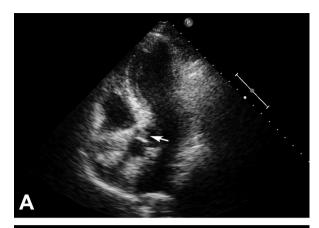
Transthoracic echocardiography (A) revealed a suspicious lesion (arrow) on the aortic valve. Transesophageal echocardiography (B) confirmed vegetation (arrow) on the ventricular surface of the aortic valve.
